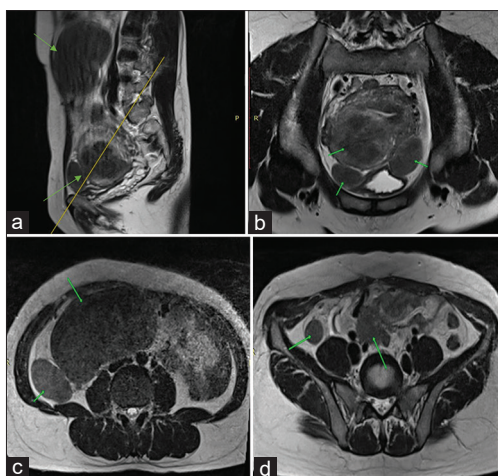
Magnetic resonance imaging shows the multi-focal masses (green arrow) in the abdominal cavity by sagittal plane (a), and in the uterus by transverse plane (b), besides the abdominal aorta and posterior side of the caecum (c), anterior site of psoas muscle and before the right common iliac arteries (d)
